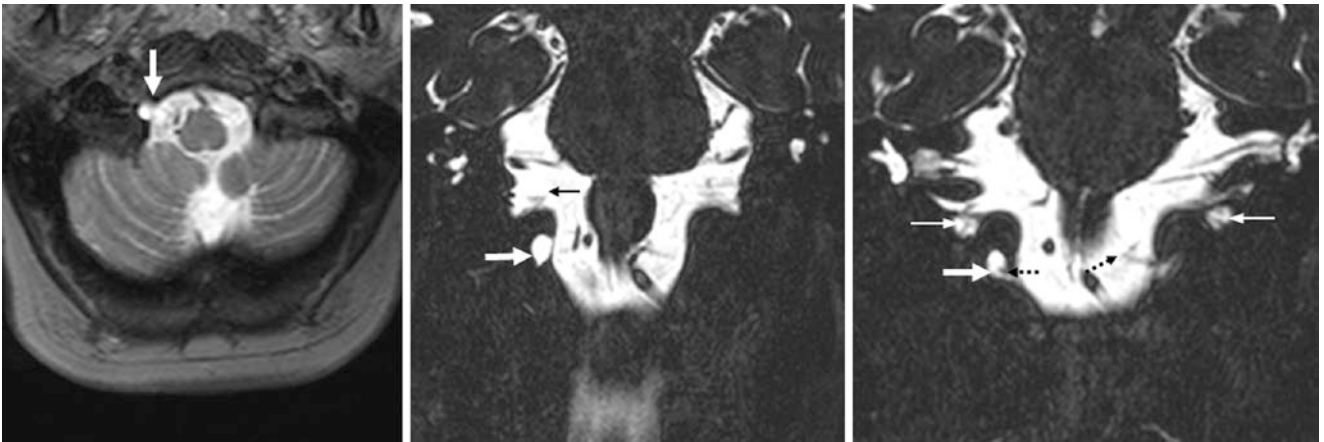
A 45 year old with an asymmetric, CSF-filled right hypoglossal canal (*arrows*) on axial T2WI MRI (*left*) with coronal reformats from a 3D T2WI acquisition (*right two images*). Note cranial nerves X (*thin arrows*) and XII (*dotted arrows*)
